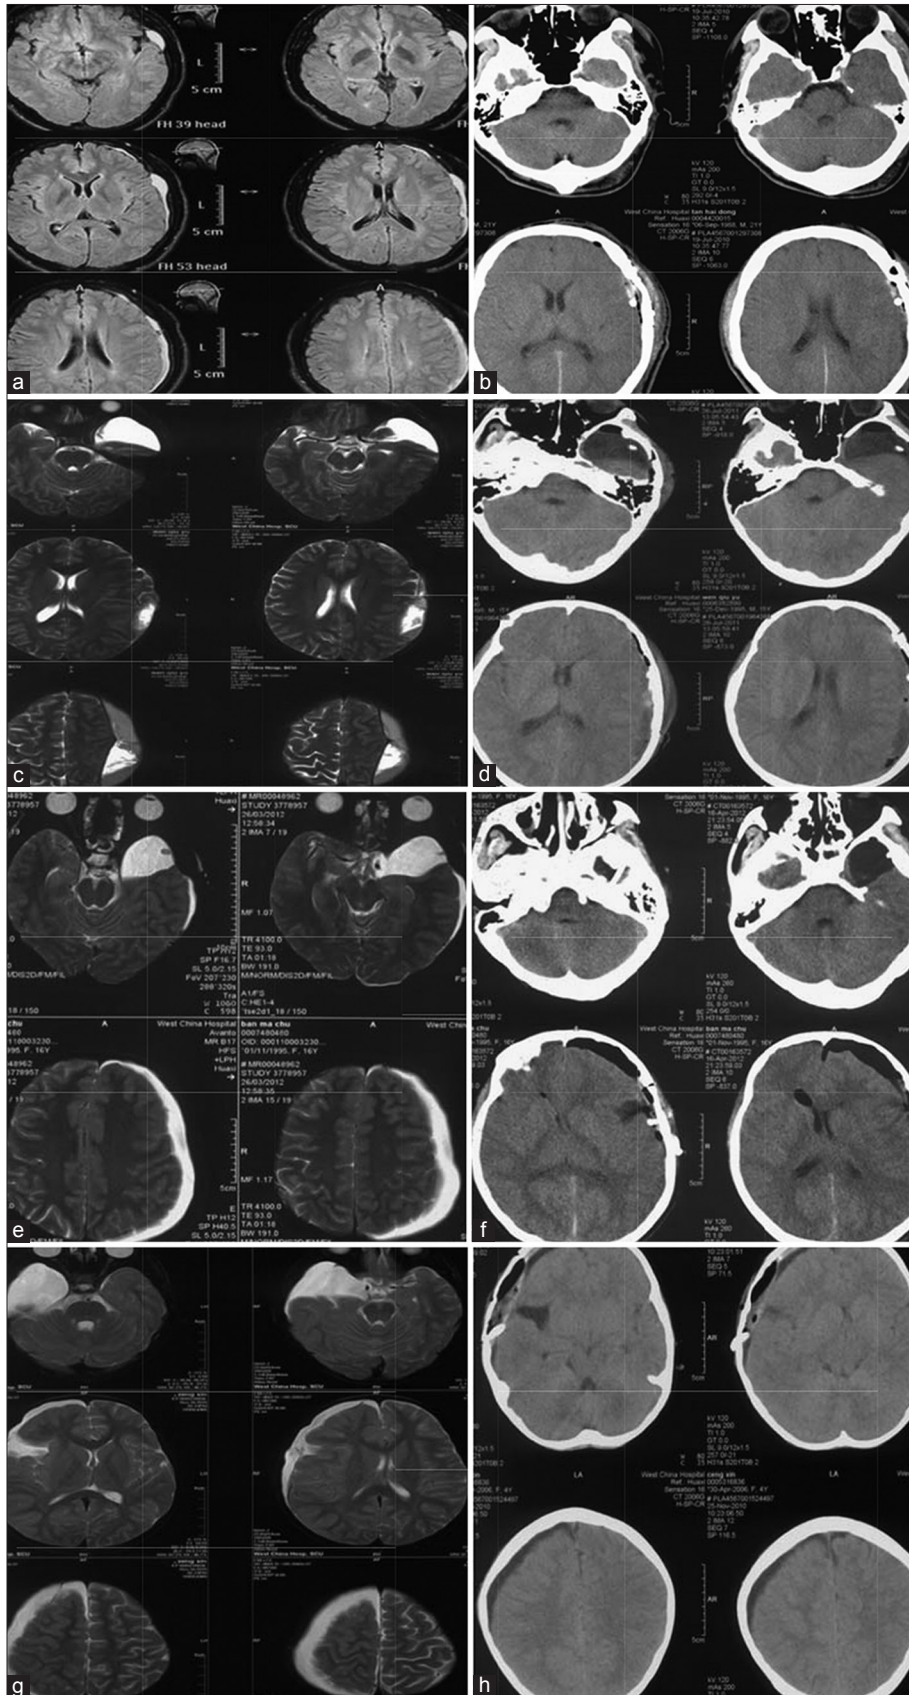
Magnetic resonance examination of brain (A, Patient 1; C, Patient 2; E, Patient 3 and G, Patient 4) showing chronic subdural hematoma and arachnoid cyst. And a postoperative computed tomography scan (B, Patient 1; D, Patient 2; F, Patient 3 and H, Patient 4) shows the absence of subdural hematoma and an arachnoid cyst
